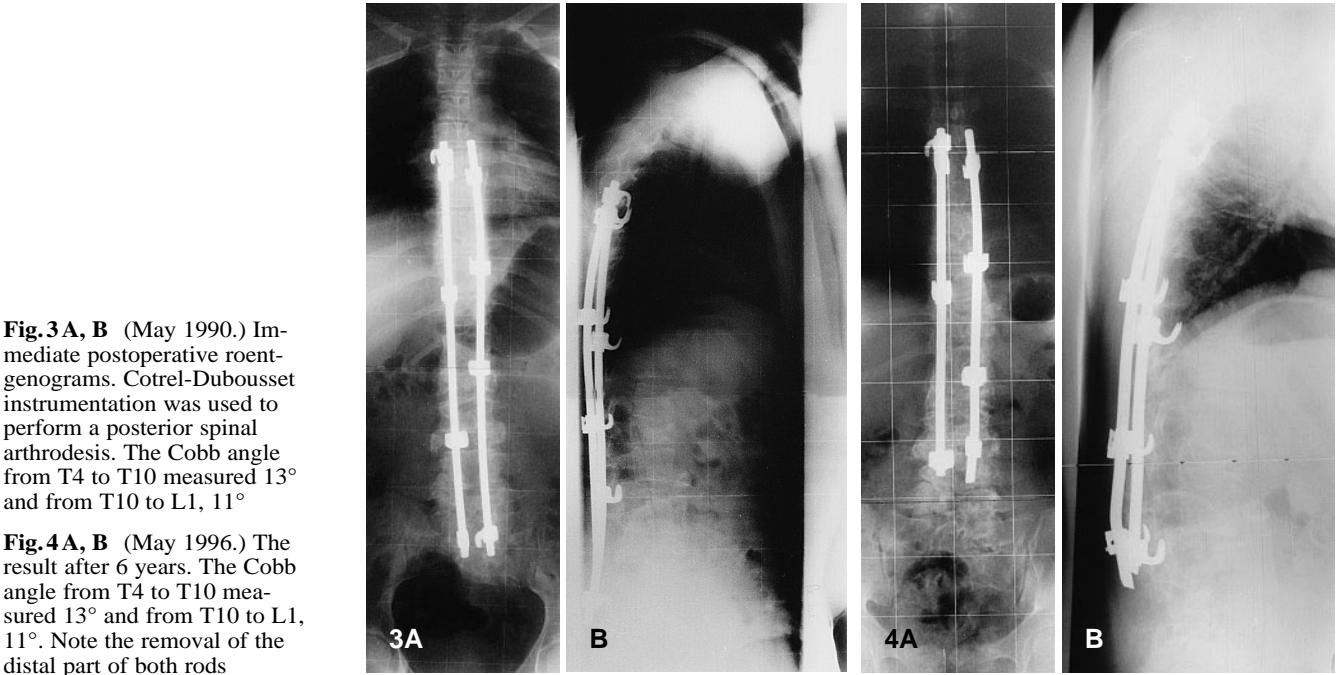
A, B (May 1990.) Immediate postoperative roentgenograms. Cotrel-Dubousset instrumentation was used to perform a posterior spinal arthrodesis. The Cobb angle from T4 to T10 measured 13° and from T10 to L1, 11°
